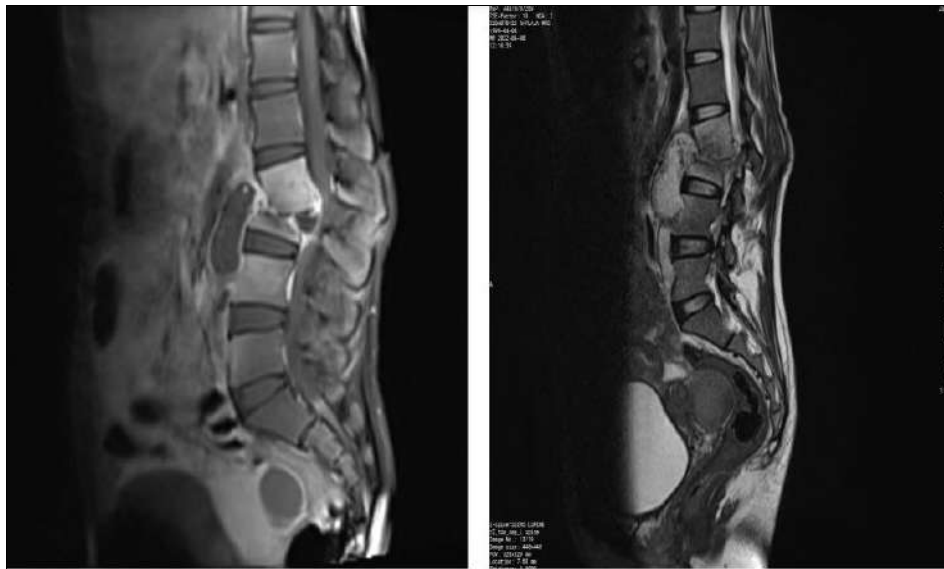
A sagittal T1 and T2 MR image of LS spine showing infective spondylodiscitis of L2-3 vertebra with pre and paravertebral collection, bilateral, psoas abscess and Tubo ovarian Abscess features are suggestive of Potts Spine
